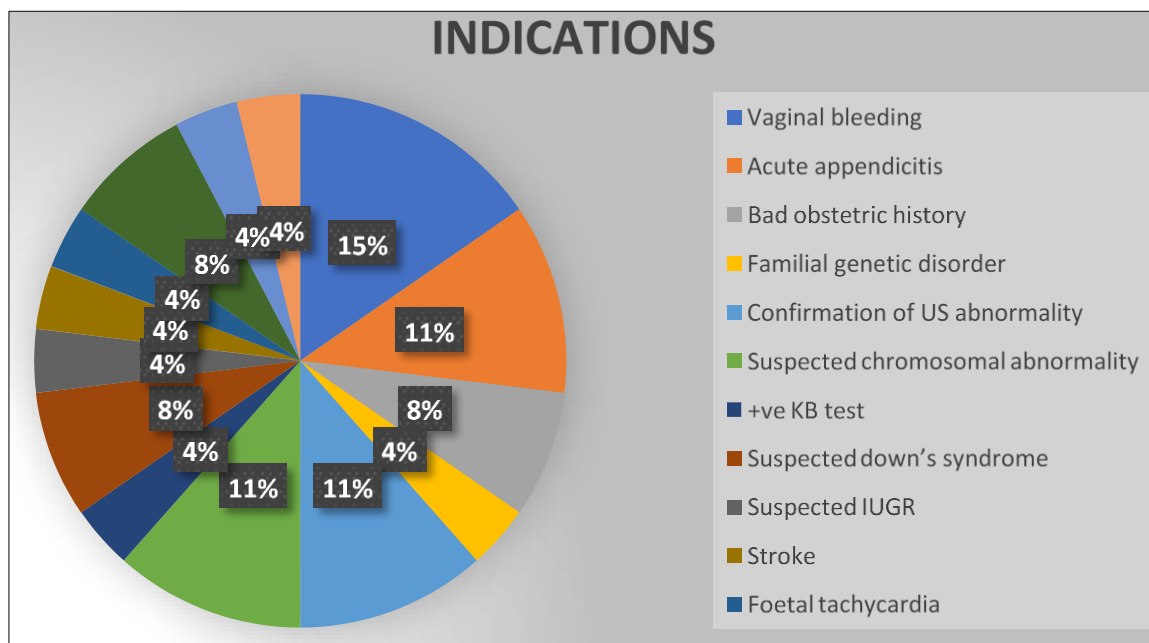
Distribution of Specific Clinical Indications for MRI in Pregnancy
